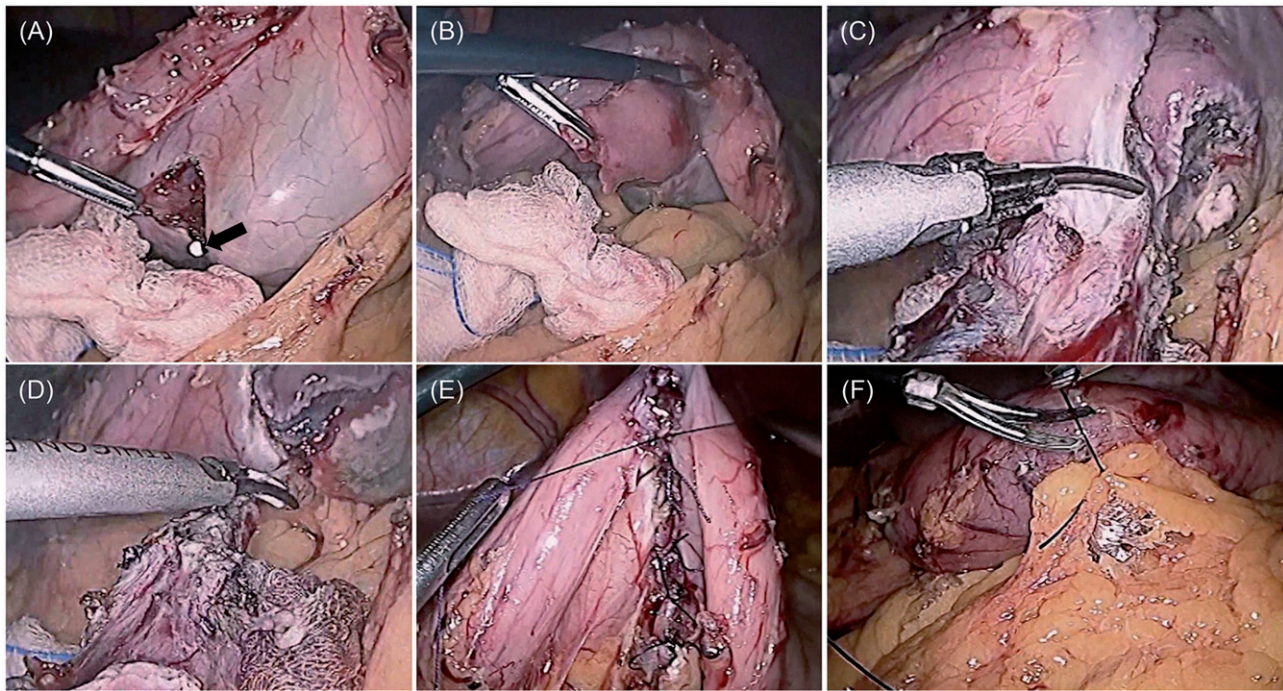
The laparoscopic view of hybrid resection of a gastric subepithelial tumor. (A) Full-thickness resection of the gastric wall around the tumor. (B) The view of the tumor after the endoscopic resection with insulated-tip knife by a half of the margin. (C and D) The resection of the margin around the tumor with an ultrasonic scissor. (E) Laparoscopic perpendicular suture of the resected margin. (F) Application of the patch of mesenteric fat at suture site.
